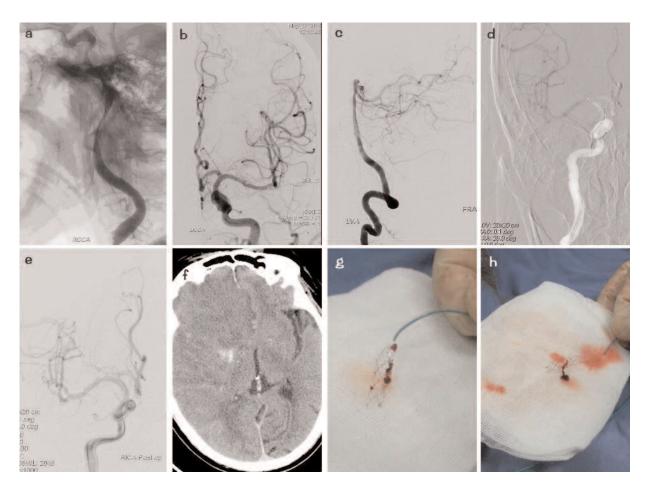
Case 7. A 79-year-old man with right ICA terminus occlusion and a history of hypertension and cardiac pacemaker. *A*, Right common carotid injection showing right ICA terminus occlusion in the lateral view. *B*, Left common carotid injection showing no cross-filling of the right anterior circulation in the anterior–posterior view. *C*, Left vertebral artery injection showing no cross-filling of the right posterior communicating artery in the lateral view. *D*, Right ICA angiogram showing partial arterial recanalization after stent deployment in the right MCA and ICA terminus in the anterior–posterior view (transient endovascular bypass). *E*, Final angiogram showing complete revascularization of the right ICA and all of its branches in the anterior–posterior view. *F*, and *G*, Solitaire stent with retrieved clot from the first and second passes, respectively. *H*, CT scan showing diffuse brain swelling without obvious intraparenchymal hematoma.
